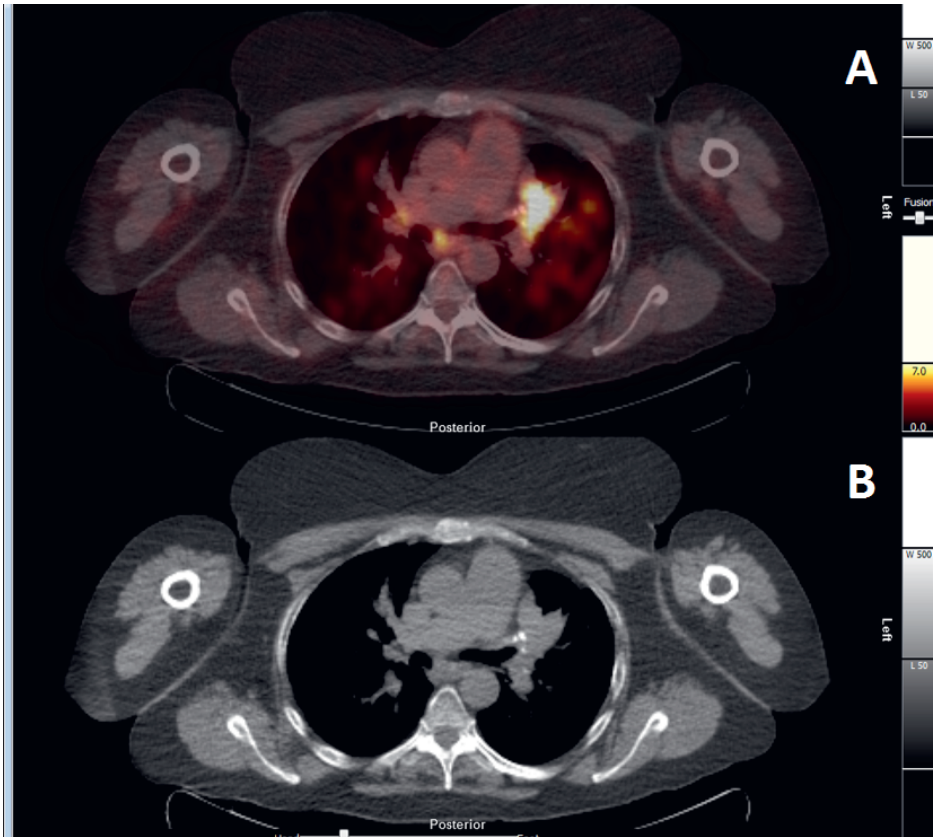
Example of compression by active disease on FDG PET/CT (A) and chest CT (B).
